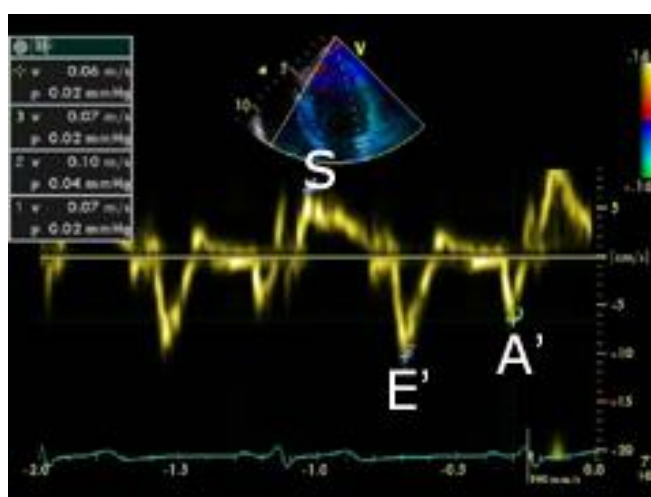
Tissue Doppler imaging.
